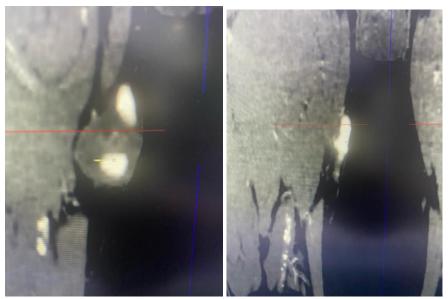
CTA showing a contrast leakage from the vein graft while maintaining proper flow to the popliteal artery
